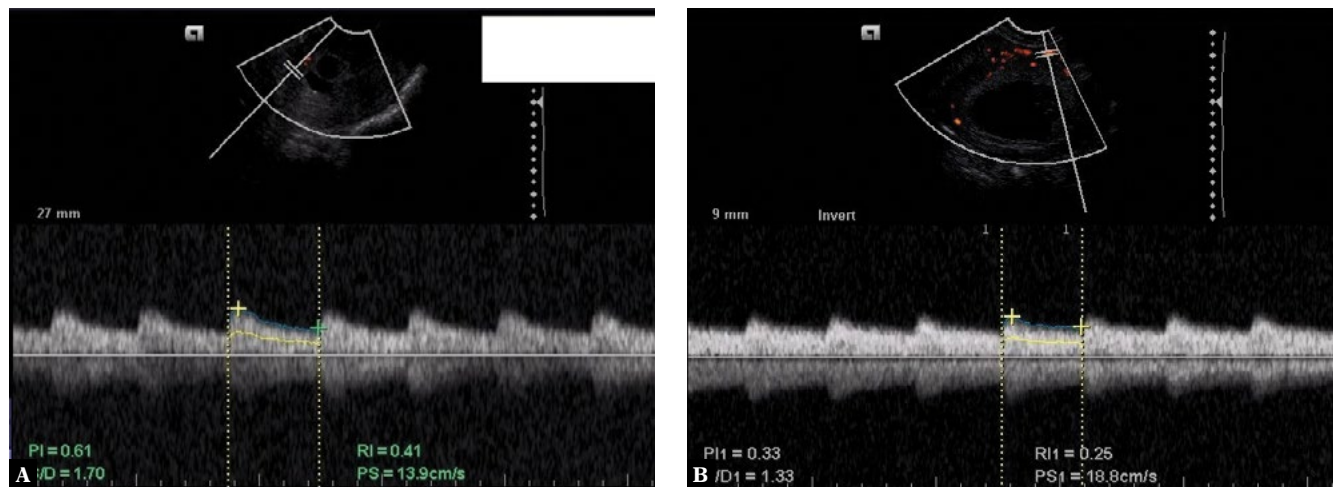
Power Doppler waveform showing the spiral arteries flow pattern in A. case of threatened abortion at 5 weeks 2 days; B. normal case at 6 weeks
